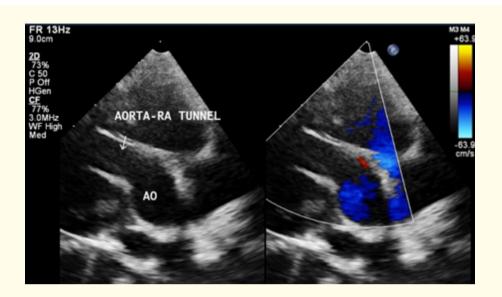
Following device closure of the aorta-right atrial tunnel, post-procedure echocardiogram.
